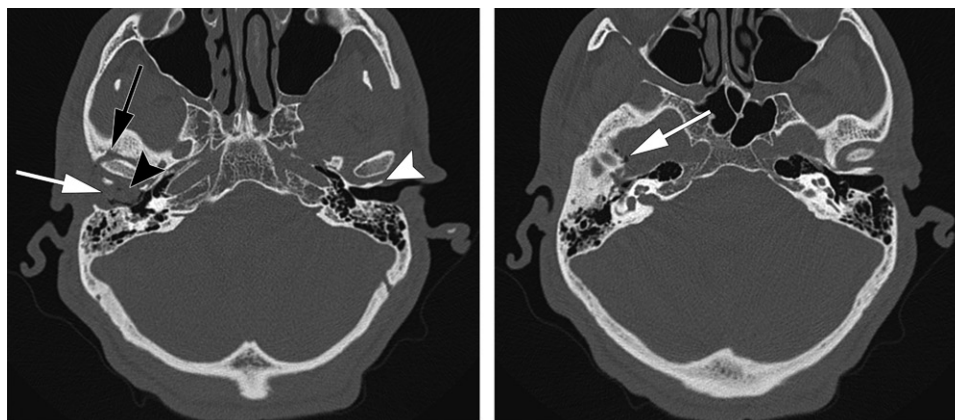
Malignant otitis externa of the right ear in a 55-year-old man. (a) Axial nonenhanced CT image shows an opacified right EAC (white arrow). There is bone erosion of the anterior wall of the right EAC, which is also the posterior wall of the temporomandibular joint (black arrowhead). In comparison, the left anterior wall of the left EAC (white arrowhead) is complete. There is also erosion of the anterior margin of the glenoid fossa (black arrow). (b) Axial nonenhanced CT image obtained superior to a shows foci of gas (arrow) in the right middle cranial fossa.
